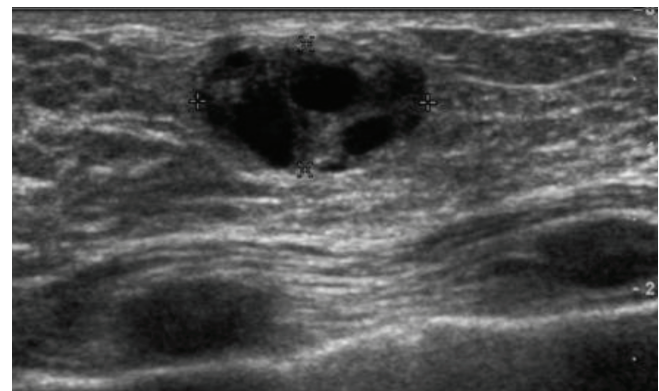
Ultrasound examination of a galactoceles
